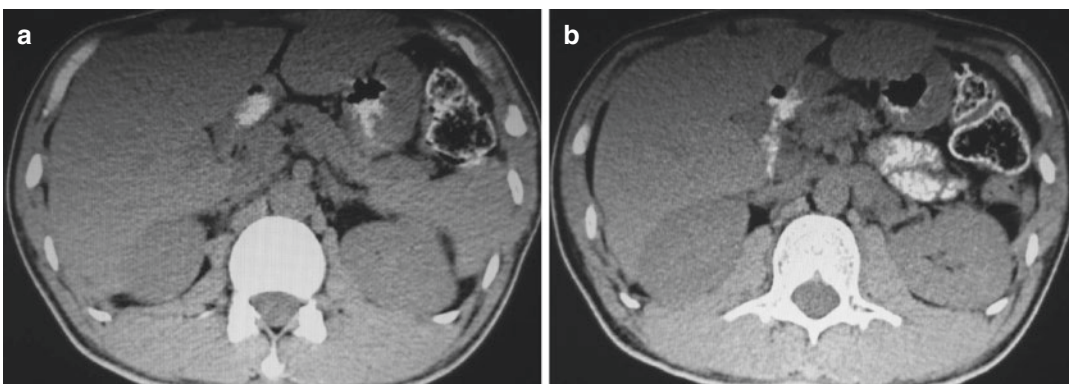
CT revealed mild pancreatic atrophy, relatively low density in the body and tail of the pancreatic parenchyma with poorly defined organ margins, and segmental dilatation of the main pancreatic duct without stones
